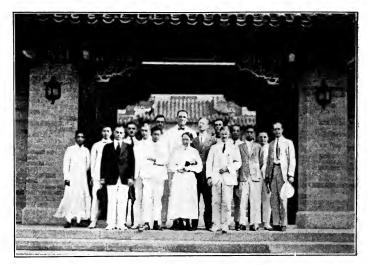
Graduate students attending summer course in roentgenology at Peking Union Medical College in 1921
